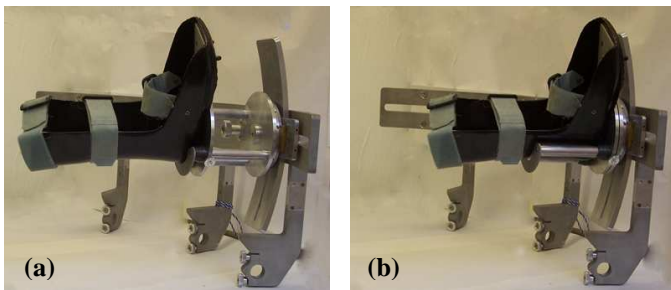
Extension channels allow the foot plate to be positioned closer to the MRI knee coil. The air cast is shown in (a) the fully extended position and (b) the fully contracted position.
